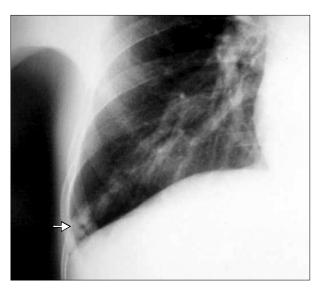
X-ray findings of the right lower lung. Prominent peripheral vascular marking with a feeding vessel is visible in the costophrenic angle of the right lower lobe (arrow).
